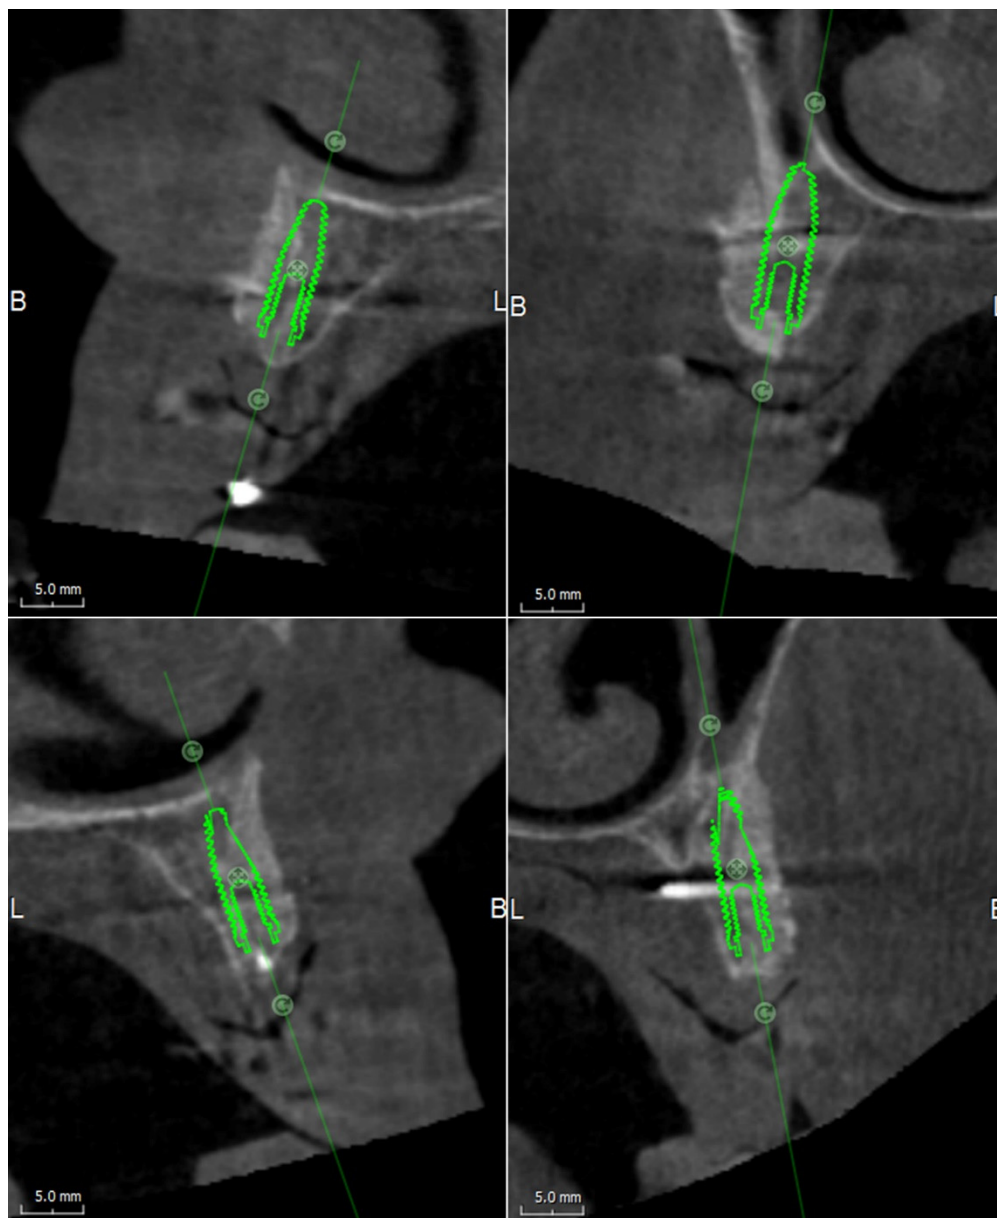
CBCT, performed at six months after reconstructive surgery, shows the integration of grafted blocks at planned implant sites.
